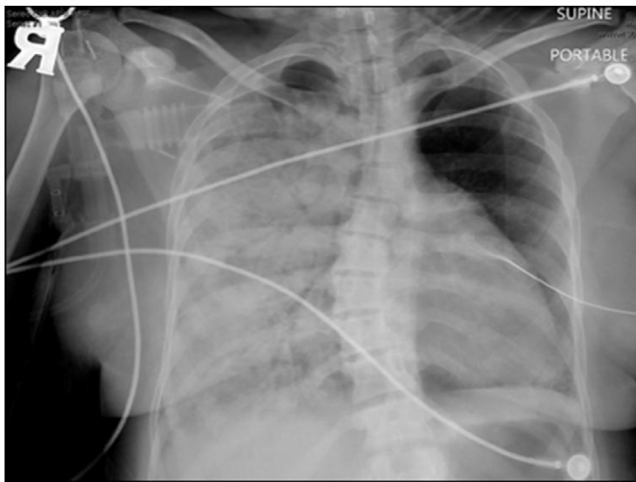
Chest-roentgenogram showing extensive infiltrates in right lung.
